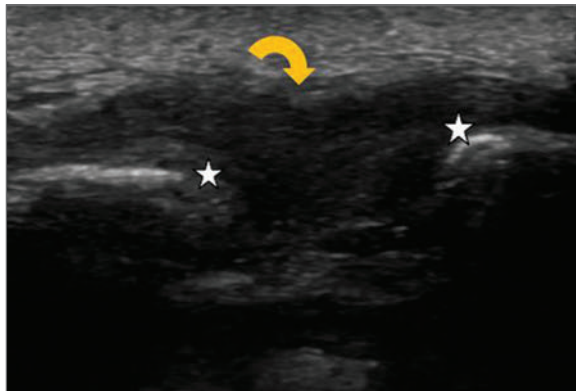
Ultrasound image of the acromioclavicular joint demonstrating increased widening of the joint (*white stars*) in keeping with previous surgical excision of the distal clavicle. In addition, hypertrophy of the capsule is seen (*curved arrow*).
